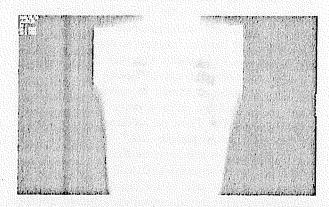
Chest radiograph 6 months after lung transplantation. The graft is fitted to the thorax of the recipient. Right ventricular enlargement is diminished compared to that on the preoperative chest radiograph
